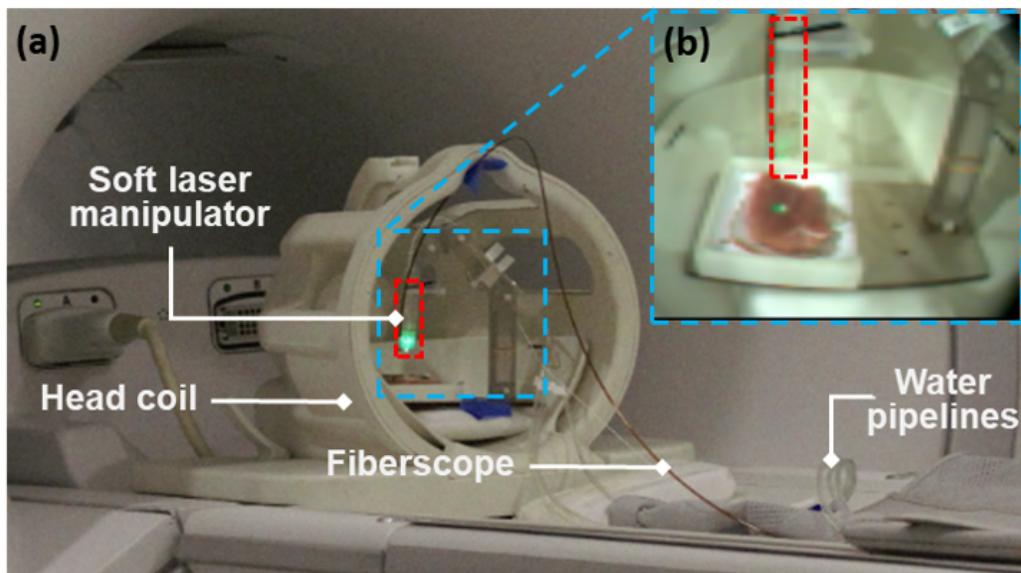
(a) Experimental setup of the soft laser manipulator in a 1.5T MRI scanner. (b) Image captured by an MR-conditional camera.
